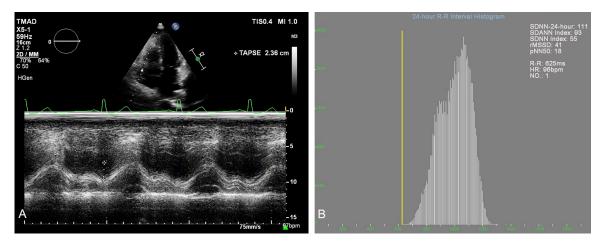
TAPSE and HRV related index images detected by echocardiography. A. Echocardiographic images of TAPSE; B. Echocardiographic images of HRV. TAPSE, tricuspid annular plane systolic excursion; HRV, heart rate variability.
